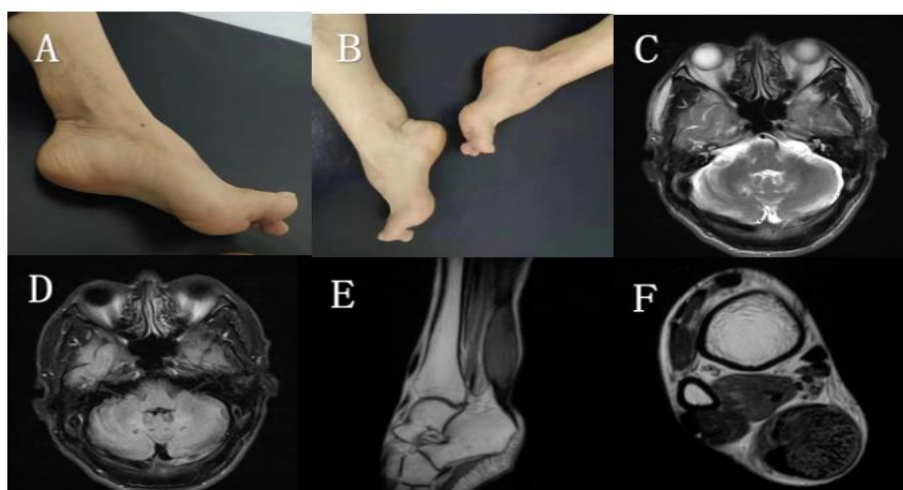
Figure A, Figure B These two pictures showed arched feet and egg-sized, hard, painless lumps in both Achilles tendons; Figure C, Figure D MRI of the brain showed T2-weighted and FLAIR imaging hyperintensity in the bilateral cerebellar dentate nuclei.; Figure E, Figure F MRI of the right ankle showed fusiform swelling and abnormal signals in the Achilles tendons.
